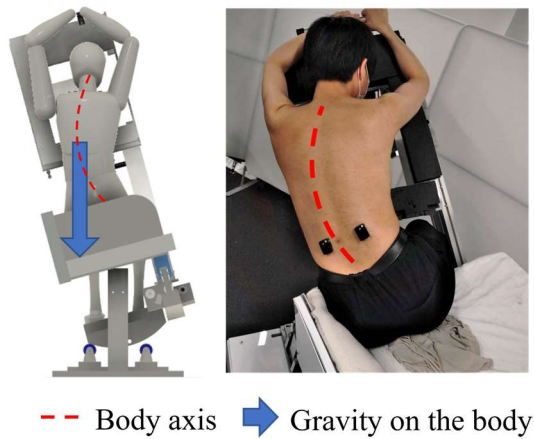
Subjects on the echocardiography robot during body bending (a) Model (b) Actual passenger
